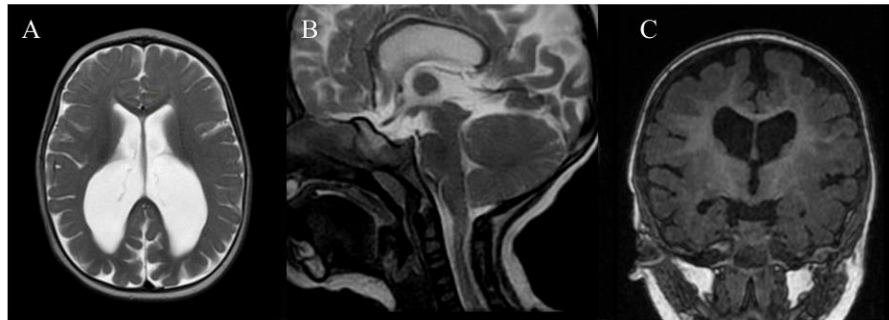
MRI imaging at 12 months of life showing A) Axial T2 showing colpocephaly of occipital horns of lateral ventricles without evidence of hydrocephalus B) mid-sagittal T2 showing improved hindbrain herniation with minimal Chiari malformation C) coronal T1 showing ventriculomegaly stable compared to prior MRI, with preserved extra-axial spaces.
